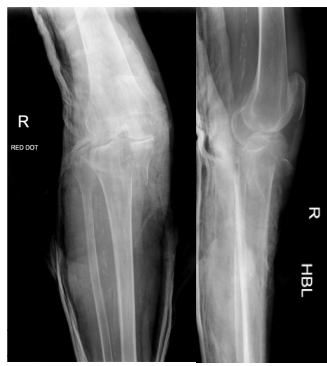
Pre-operative radiographs showing displaced medial tibial plateau fracture. (a) Anteroposterior view, (b) lateral view.
